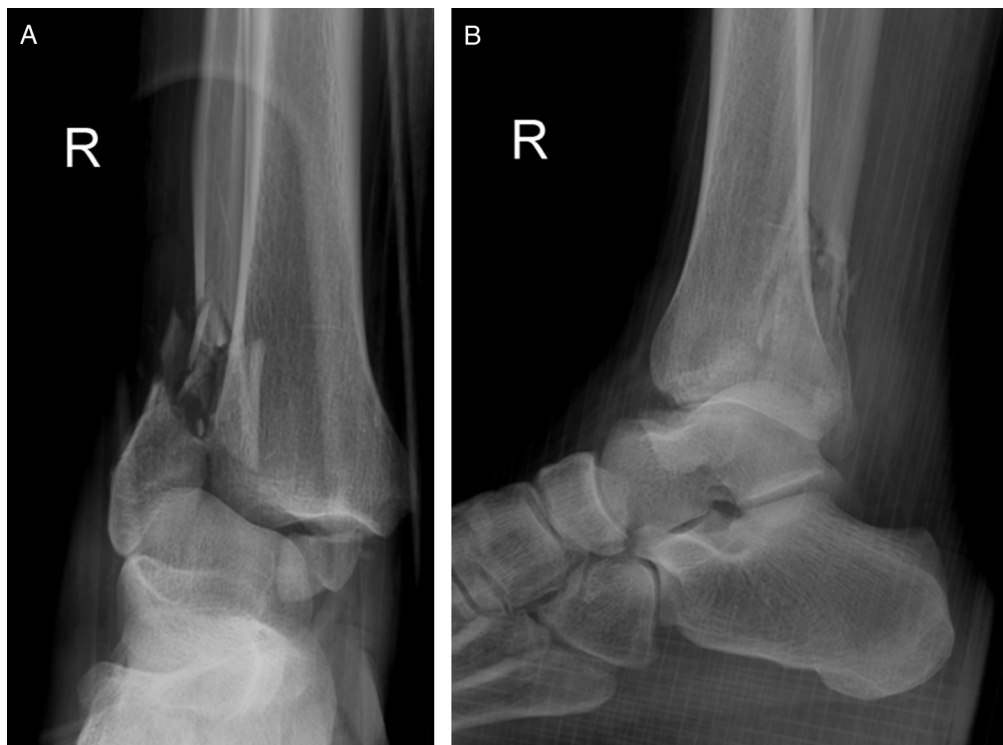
(A) Anteroposterior and (B) lateral radiographs of right ankle fracture-dislocation.
